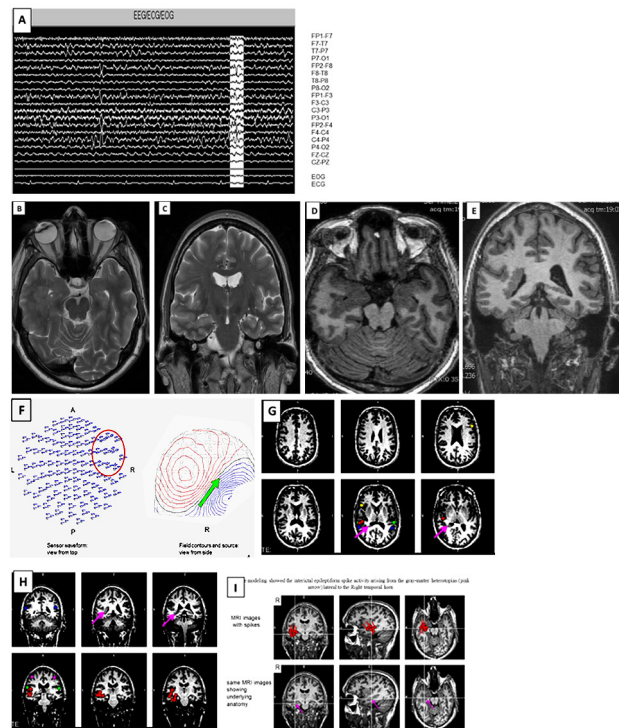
(A) Initial vEEG demonstrates lateralization to the right hemisphere with epileptiform spikes in the right temporal and frontal lobes. (B), (C), are T2W MRI whereas (D), (E) are 3D Vol SPGR MRI showing extensive gray matter heterotopia along the temporal horn and posterior body of the right lateral ventricle-right ventricular heterotopia (curved arrows) with several adjacent areas of abnormal overlying cortex, in the right temporal and posterior frontal lobes. (F) demonstrates MEG raw with a right temporal spike. (G), (H) Key shows; Red-spikes, blue-wernicke's mapping, purple-median nerve response, green-auditory response, yellow-Broca's mapping. Stimulation of left and right median nerves (purple) elicited cortical responses with age-appropriate latency and distribution in the right and left postcentralgyri. The language mapping task indicated the receptive-language-specific cortex in the patient localized to the posterior aspect of the left and right superior temporal gyri (Wernicke's area-blue) whereas the expressive language-specific cortex (Broca's area-yellow) using picture naming localized appropriately to the left and right inferior frontal gyri. (I) shows abnormal spontaneous MEG recording. Frequent epileptiform spikes were observed during spontaneous MEG recordings when the patient was resting (46 spikes observed over 50 minutes). Source modeling showed the interictal epileptiform spike activity arising primarily from the prominent gray-matter heterotopias (red) lateral to the right temporal horn and the more-lateral associated heterotopic cortex; some spikes from the adjacent anterior right hippocampus; (purple arrows) and some spikes from the more posterolateral aspect of the right temporal lobe, some of which are close to the subtle heterotopic gray-matter of the infero-postero-medial right insula. No propagation of the spikes was observed.
